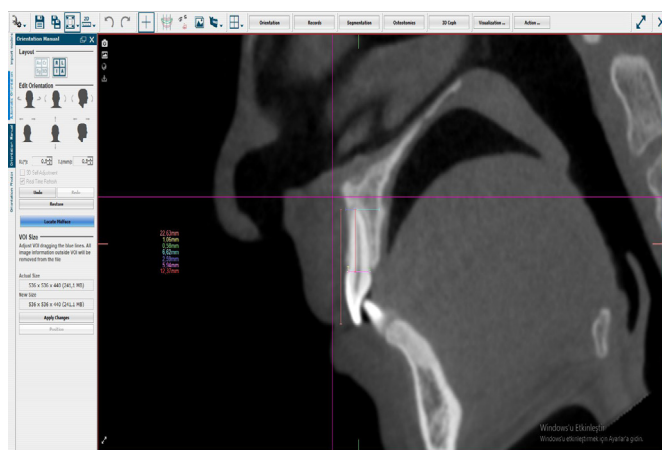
Anterior teeth measurements made on CBCT section
